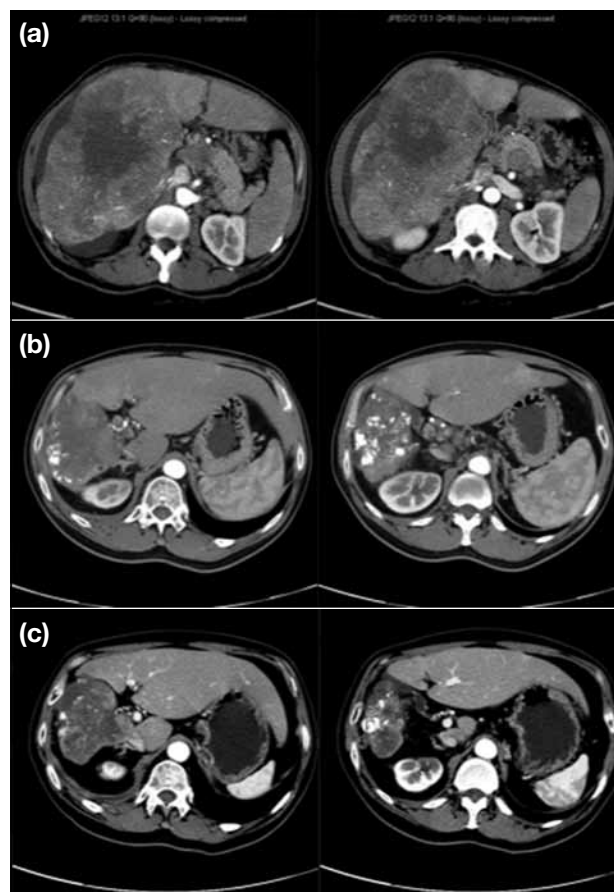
Abdominal computed tomography scans of a patient with hepatocellular carcinoma at (a) baseline, (b) 8 months after stereotactic radiotherapy, and (c) 22 months after targeted therapy.
